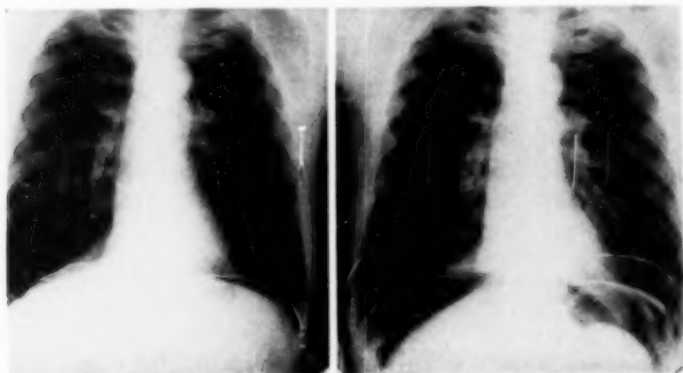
Case 5: From x-ray films showing limits of maximal diaphragm excursion before and after pneumoperitoneum treatment. For a description of technique, see legend, figure 2.
